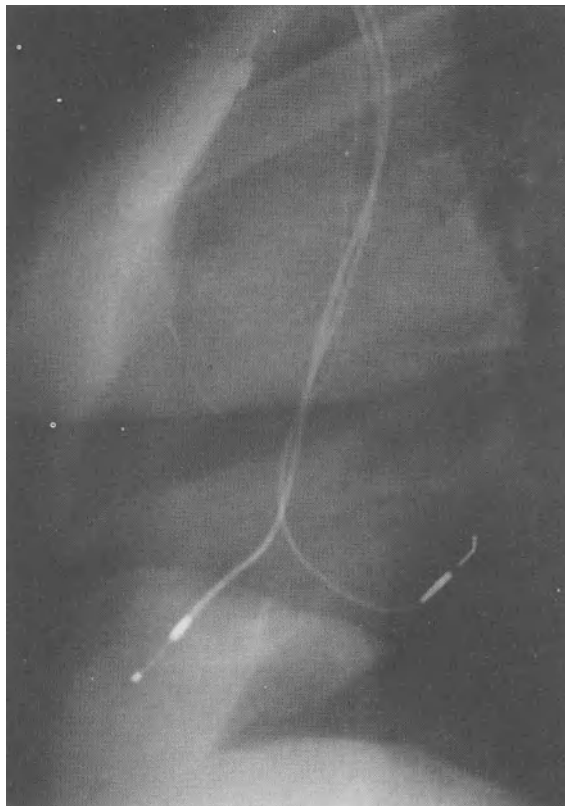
"Triple-chamber" pacemaker. Chest X-ray in a sagittal view showing three transvenous leads placed in the high right atrium, in the mid part of the coronary sinus (to sense and to pace the left atrium), and at the very apex of the right ventricle
